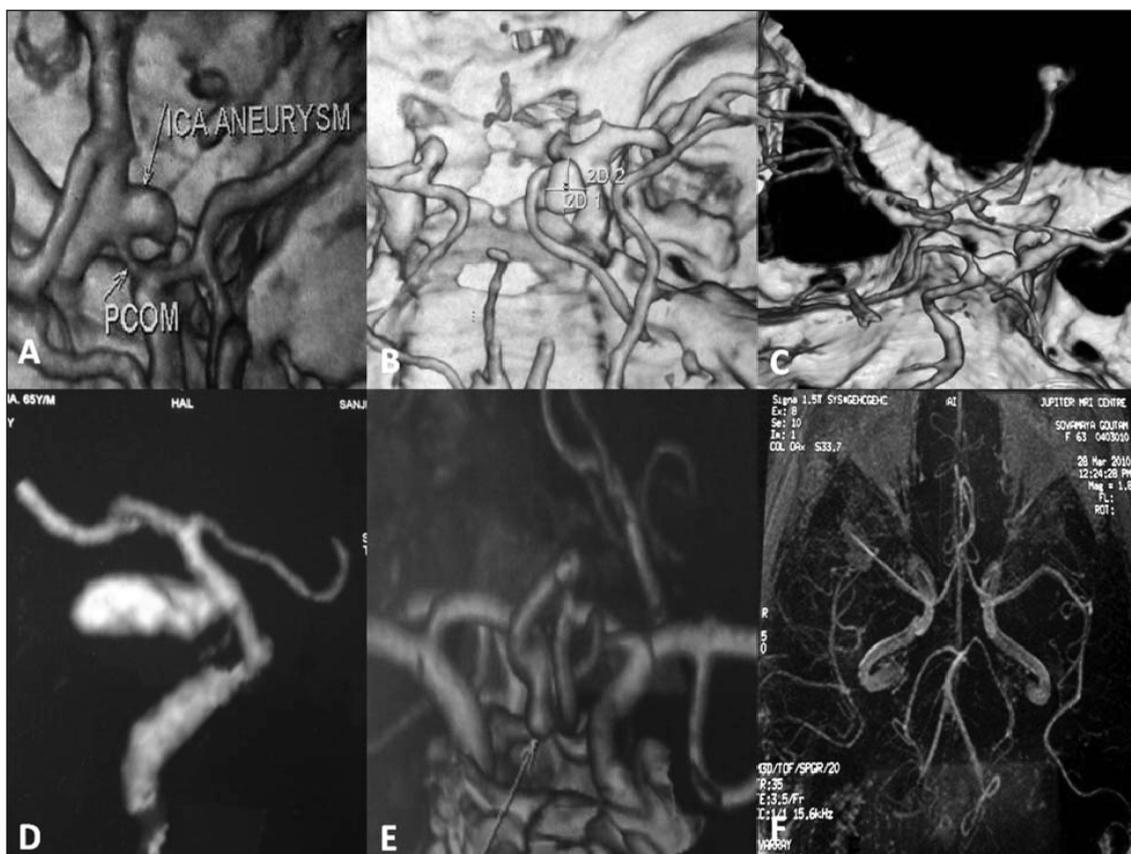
CTA showing the various locations of aneurysms ICA(a), ICA bifurcation(b), Distal A2(c), giant ICA (d), ACOM(e) and MCA(f).
